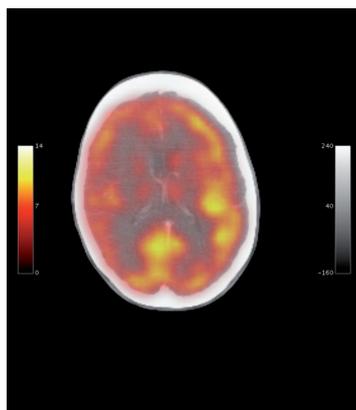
Mis-registration of PET and CT image data on a PET/CT scanner due to head movement between scans.
